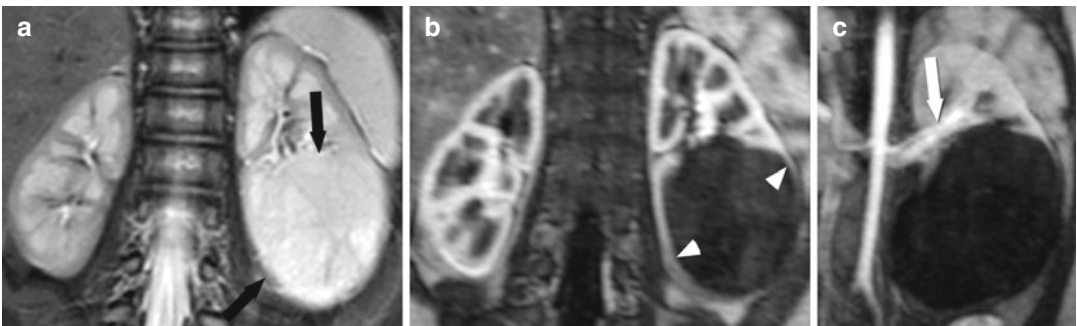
Left lower pole nephroblastoma imaged with coronal sections on MRI. (a) Fat-suppressed T2-weighted technique, the often preferred pulse sequence in adult tumor imaging, provides poor contrast between the renal tissue and the mass (*black arrows*). (b) Fast T1-weighted gradient echo sequence acquired in arterial phase
